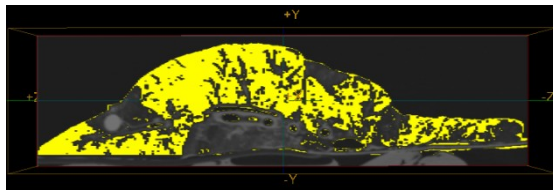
(a)-(t) each shows a tumor passing slice from the lung's 4D-CT respiratory image sequence where the air inside the lung is segmented using the obtained threshold values. These images have been displayed using MicroView open source software (GE Healthcare). The lung's air volumes corresponding to the respiratory image sequence were estimated at (a) 920 ml, (b) 826 ml, (c) 782 ml, (d) 714 ml, (e) 642 ml, (f) 573 ml, (g) 501 ml, (h) 441 ml, (i) 436 ml, (j) 359 ml, (k) 347 ml, (l) 375 ml, (m) 445 ml, (n) 532 ml, (o) 728 ml, (p) 802 ml, (q) 878 ml, (r) 949 ml, (s) 982 ml, (t) 989 ml, respectively. The gradual air volume variation inside the lung is evident in this sequence. This is consistent with the gradual variation seen in the combined sequence histogram.
